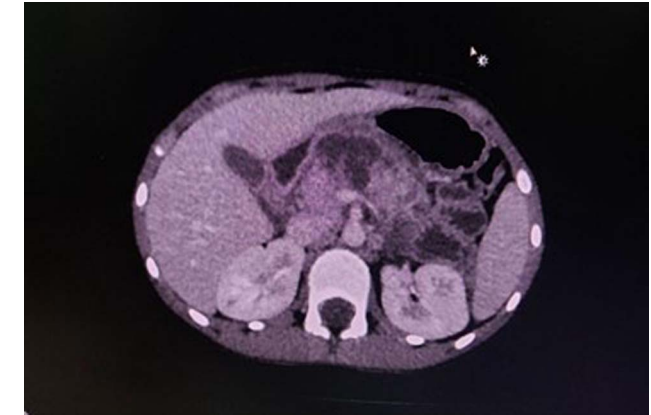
Computed tomography scan of the abdomen showing pancreatic necrosis.
